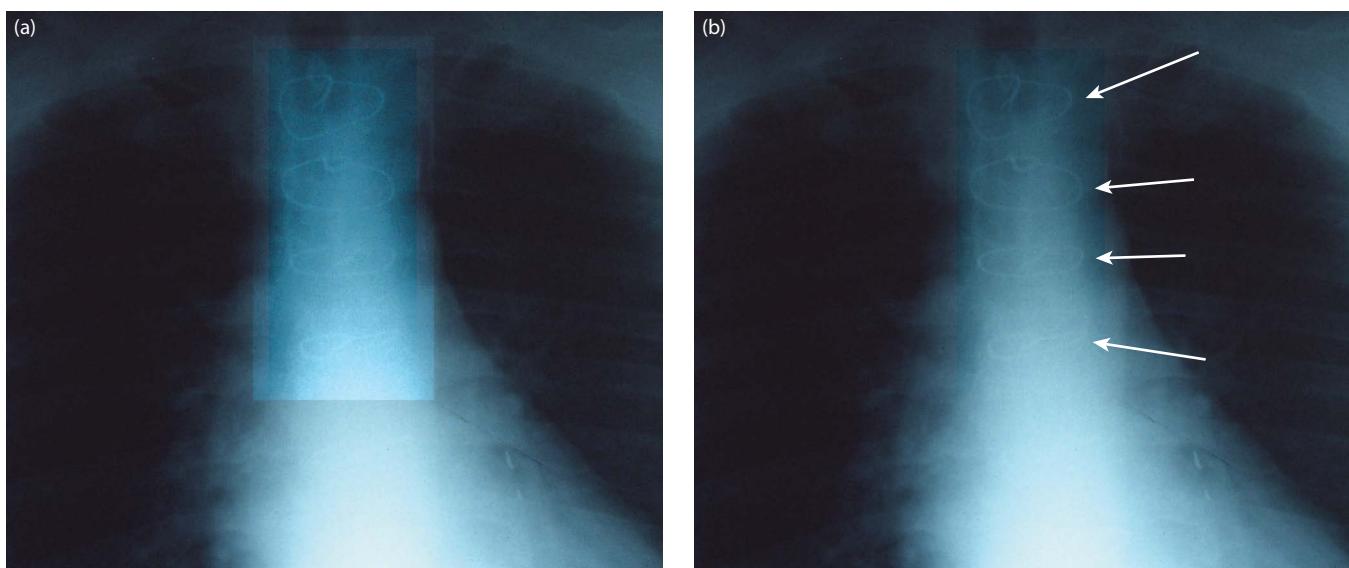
Radiograph of surgical sternal wires. Surgical wires and devices, when somewhat unique, can aid in identification when old comparison films are present. The old comparison film (a) shows an almost identical twisting pattern to the autopsy film (b).
